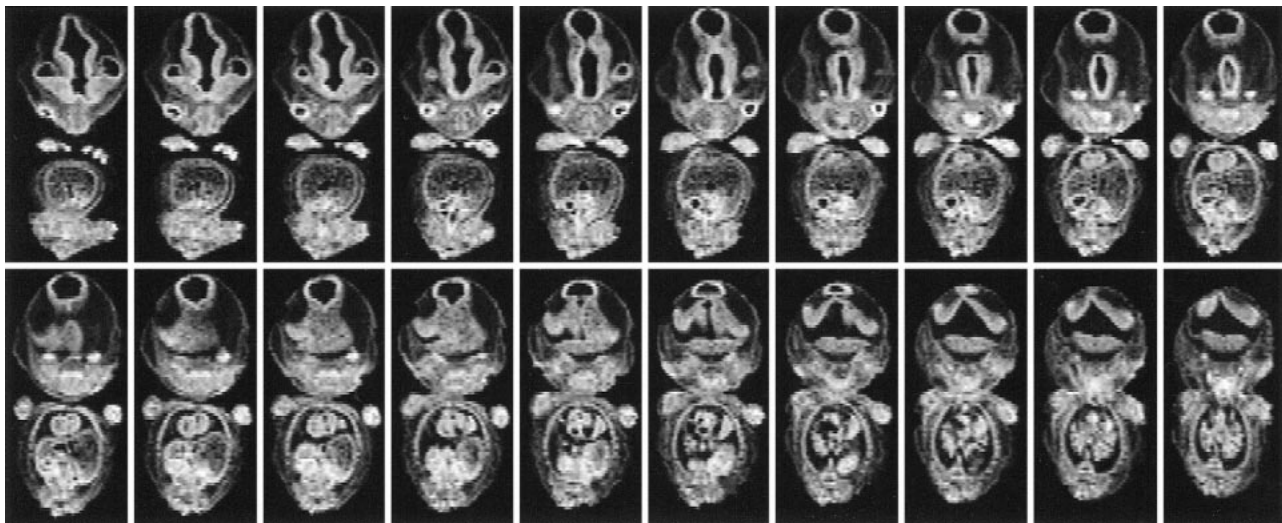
Serial coronal MR images of the fetus at 7 weeks' GA. Germinal matrix cannot be detected.
